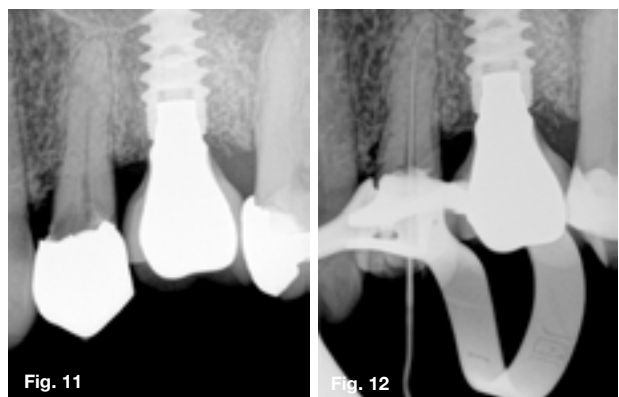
A peri-apical radiograph of a maxillary left first premolar, with extensive decay under a previously placed porcelain veneered crown.
